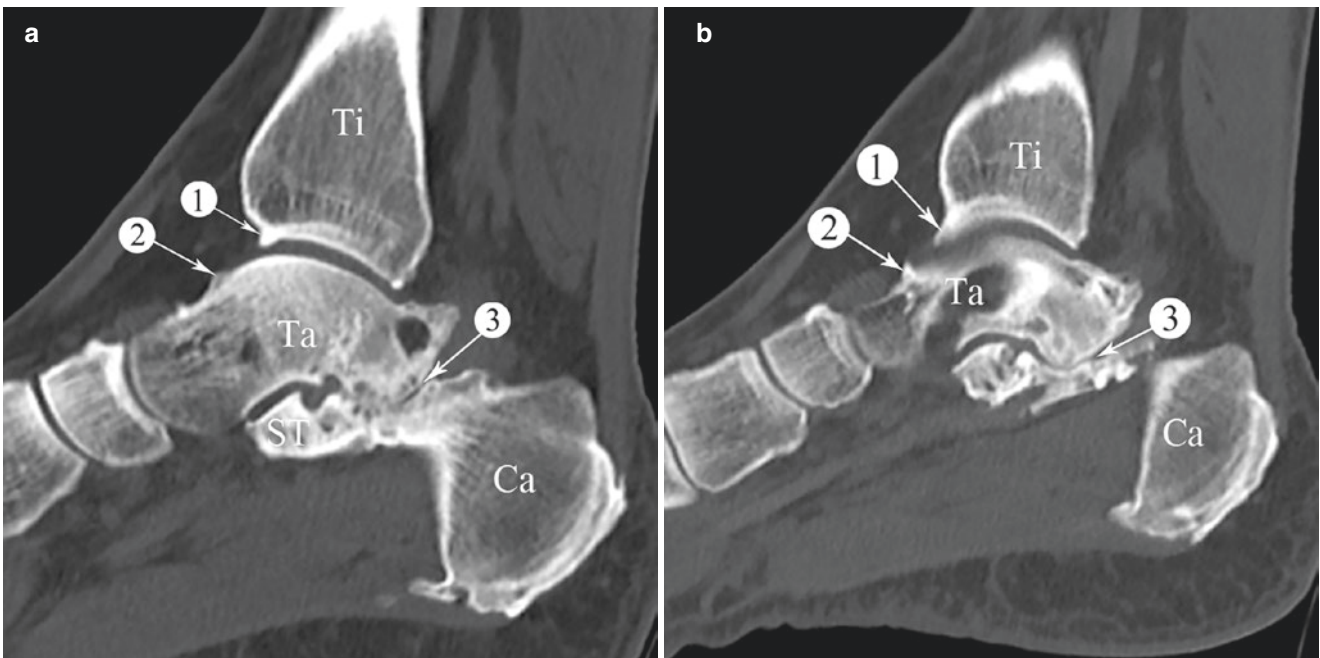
(a, b) Sagittal view of the ankle joint (CT). (c) Sagittal view of the ankle joint (MRI T2WI). *Ti* tibia, *Ta* talus, *Ca* calcaneus, *ST* sustentaculum tali. (1) Osteophyte of the tibia. (2) Osteophyte of the talus.
